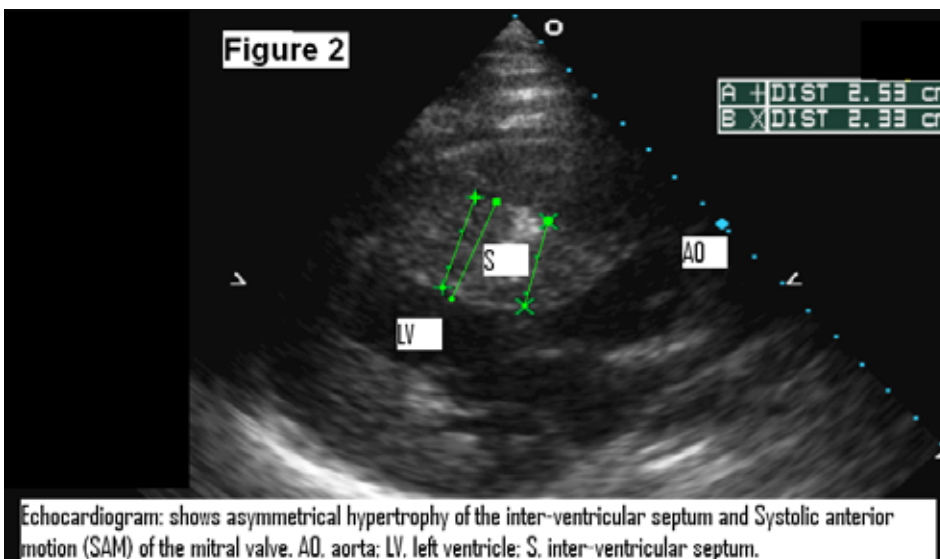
Echocardiogram shows asymmetrical hypertrophy of the inter-ventricular septum and Systolic anterior motion (SAM) of the mitral valve.
